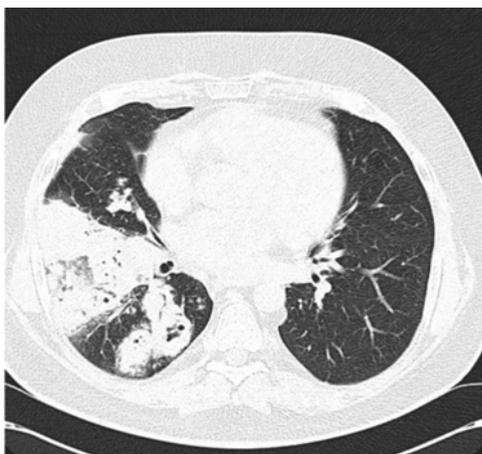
CT scan of chest showing nodules with central cavitations in the right upper lobe. Image courtesy of Martin Hoenigl, MD.
